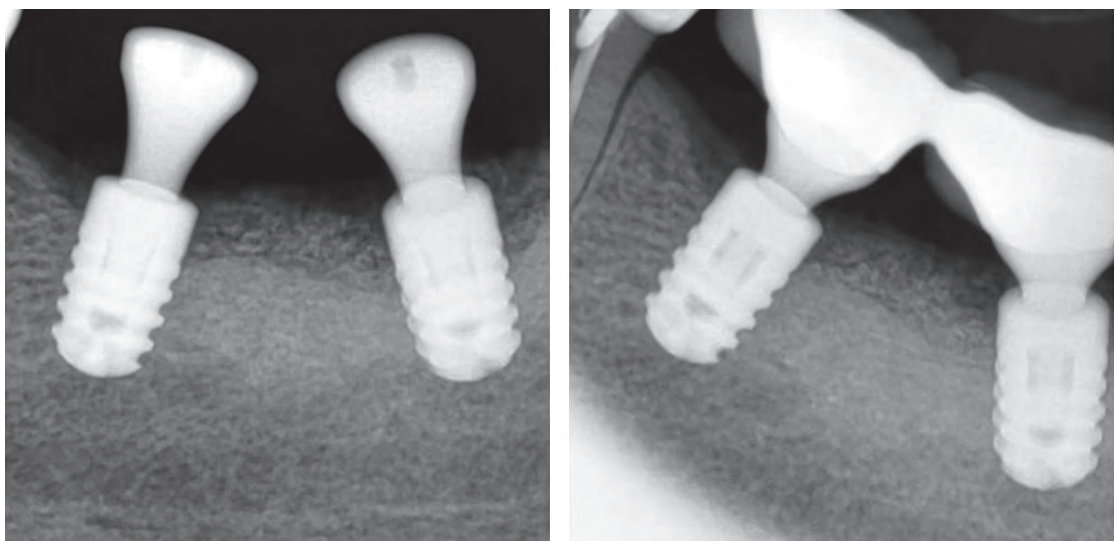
Radiographic image after the surgical treatment at the time of the procedure and 1 year after
